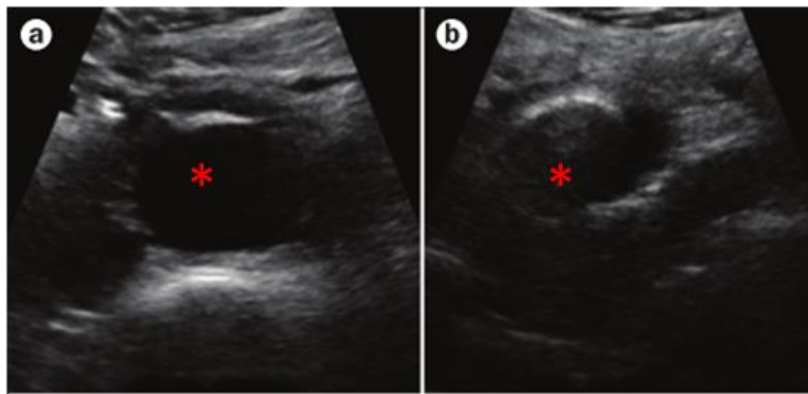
Ultrasonography showing a transverse view of the distal aorta. (Reproduced from Buck *et al.*¹⁰⁵, with permission from Springer Nature)
